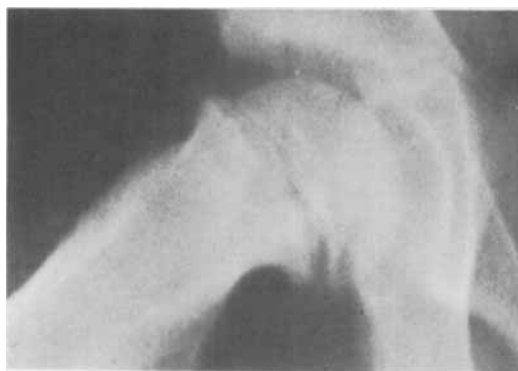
Case 1. Age 11. Radiograph showing an acute slip of the right upper femoral epiphysis.
